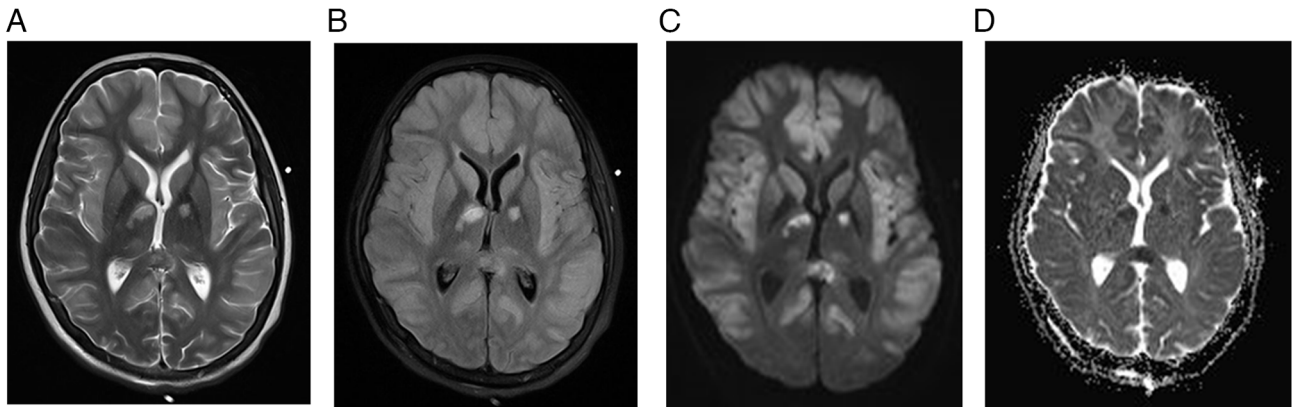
MRI brain scan for case 5. (A) T2-weighted MRI, (B) FLAIR, (C) DWI and (D) ADC map demonstrating symmetric cortical swelling with corresponding high T2 and FLAIR signal intensity involving the bilateral insular cortex, frontal lobes, parietal lobes, temporal lobes and cingulate gyri, with corresponding diffusion restriction. The bilateral occipital lobes and deep grey matter nuclei are spared. At the level of the vertex, (E) T2-weighted MRI, (F) FLAIR, (G) DWI and (H) ADC map demonstrating similar asymmetric cortical swelling, with high T2 and FLAIR signal intensities involving the frontal and parietal lobes, with corresponding restricted diffusion. The bilateral peri-rolandic regions are spared. MRI, magnetic resonance imaging; FLAIR, fluid attenuated inversion recovery; DWI, diffusion-weighted imaging; ADC, apparent diffusion coefficient.
